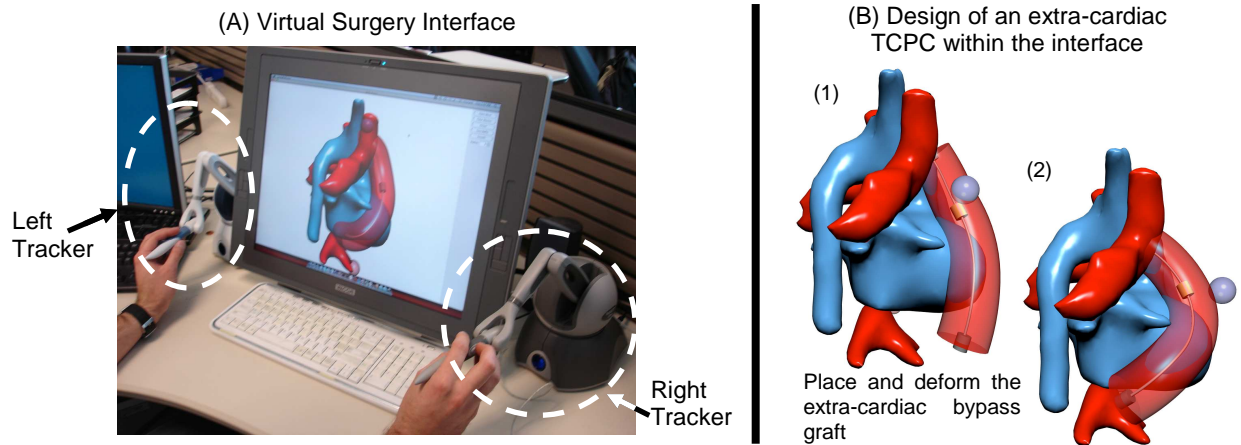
Example of a virtual surgery application. Patient TCPC (shown in red) and surrounding anatomical structures, such as the heart and great vessels (shown in blue), have been reconstructed from MRI and loaded into the virtual-surgical interface. Using two haptic trackers, one in each hand, the user/surgeon may directly interact with the geometry, here placing and deforming an artificial graft to complete the TCPC.
